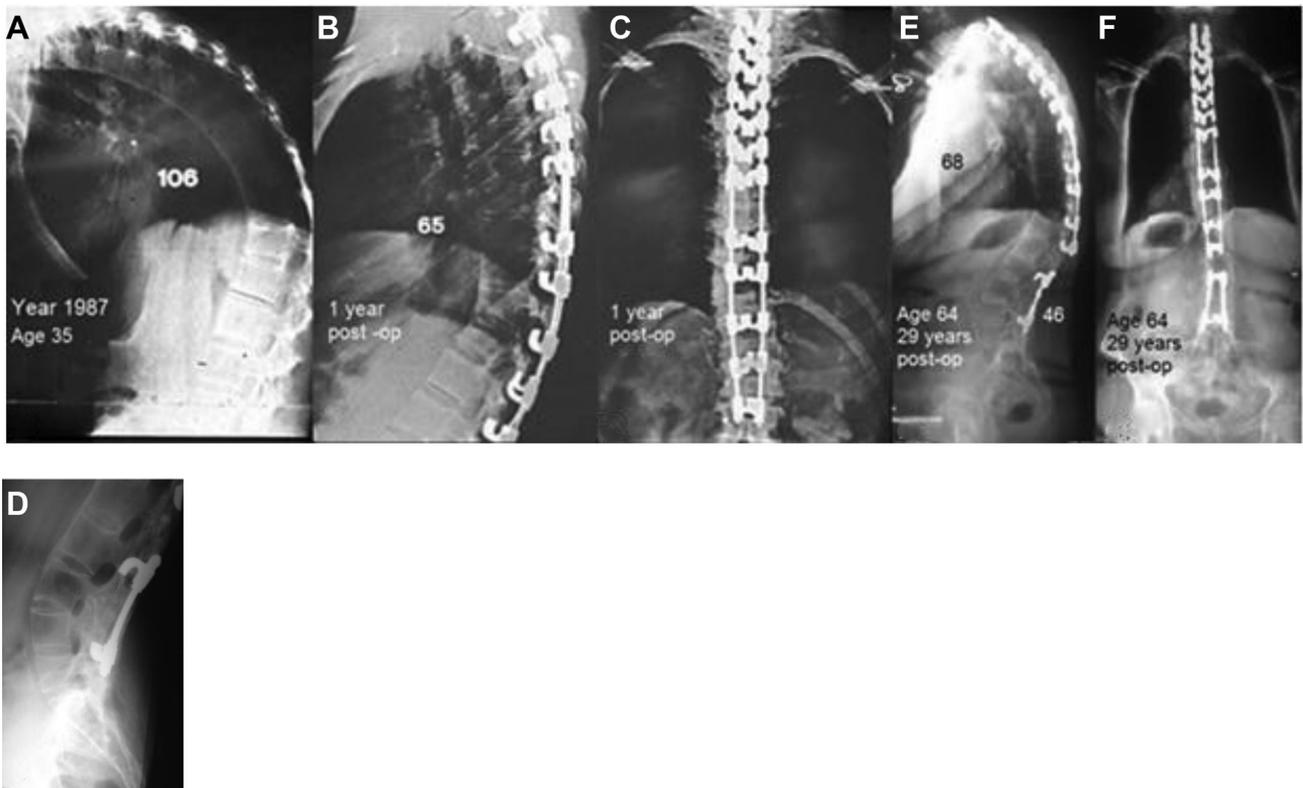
A 35-year-old female patient. Hyperkyphosis from ankylosing spondylitis developing in 3 years. Inability to look straight ahead, rapid progression, major functional restrictions, interference with having sexual intercourse, were the indications for surgery. Extreme rigidity of the deformity, ossification of ligaments, marked softness and heavy bleeding of the vertebral bone were present at surgery. Twelve levels of Ponte osteotomy and a 24 laminar hook compression system obtained correction of the primary thoracic deformity by bending the ossified anterior longitudinal ligament. (A) Year 1987. Preoperative standing lateral radiograph. No long radiographs then. (B) One-year postoperative standing lateral radiograph. (C) One-year postoperative standing AP radiograph. (D) A two-level lumbar Smith-Petersen osteotomy L2–L3 and L3–L4 had been performed 14 months after the thoracic procedure, with removal of the 2 laminar hooks on L1 (no way to connect the two types of instrumentation, no long radiographs then). (E) Age 64. A 29-year follow-up standing lateral radiograph showing maintenance of correction. This in spite of the marked progressiveness of kyphosis in this pathology. (F) A 29-year postoperative standing AP radiograph. AP, anteroposterior.
